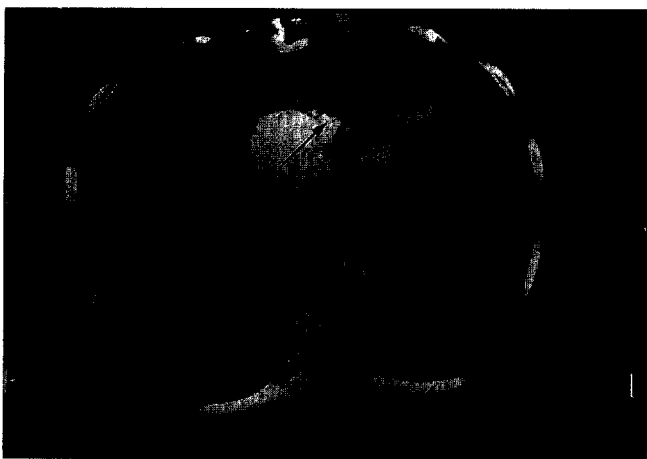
CT scan with contrast in patient 11 showing filling defect (*arrow*) in the right middle lobar pulmonary artery.
